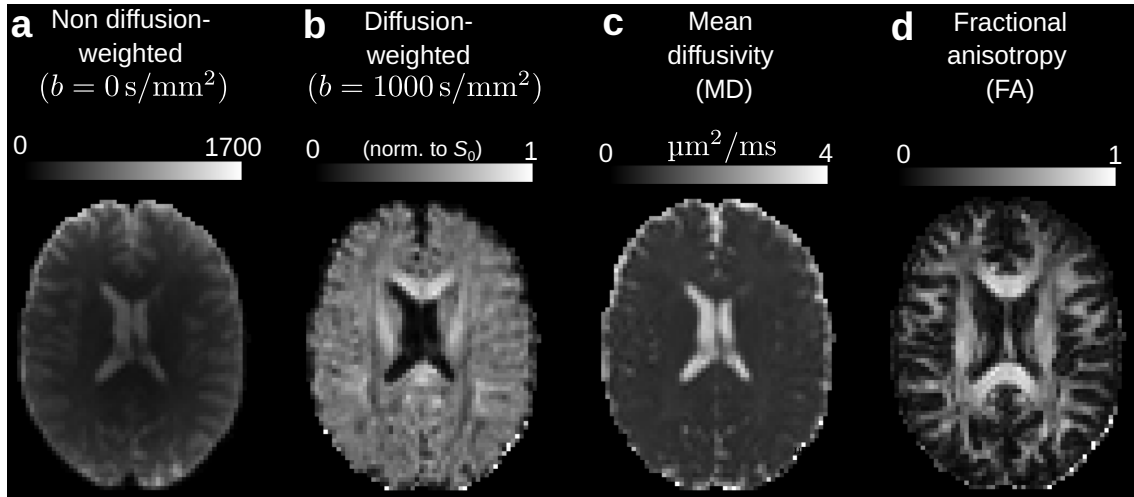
Diffusion tensor imaging. (a-b) Exemplary MRI images without (a) and with (b) diffusion-weighting. (c-d) Derived metrics from DTI: (c) mean diffusivity (MD) and (d) fractional anisotropy (FA). Metrics were computed over 30 diffusion-weighted images as in (a). All images show axial views of the brain.
